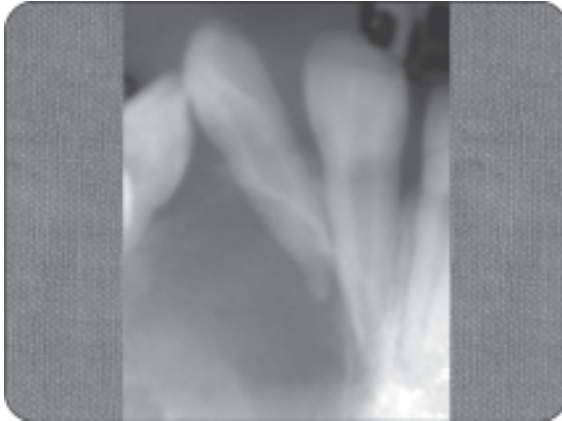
Radiograph of globulomaxillary cyst
